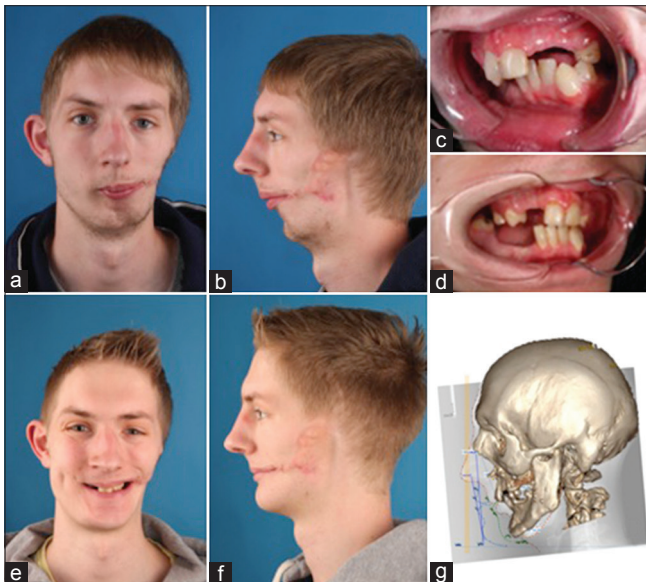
Pruzansky-Kaban Type III case undergoing a facial rotation procedure. The ideal profile line according to www.facewizz.com is coloured blue (g). The targeted profile is colored green. (a) Frontal view, relaxed, before facial rotation; (b) left profile view, relaxed, before facial rotation; (c) three-fourths profile view of the dental occlusion, before facial rotation; (d) three-fourths profile view of the dental occlusion, after facial rotation. Proper prosthetic rehabilitation can be undertaken secondary to occlusal stability; (e) frontal view, smiling, after facial rotation; (f) profile view, relaxed, after facial rotation; (g) planning of the advancement. A three-dimensional (3D) computed tomography (CT) reconstruction is layered over the profile cephalogram, which was used to predict the ideal advancement (blue profile line) and the targeted advancement (green profile line), based on the risk of postoperative relapse and the consequences related to dental occlusion
